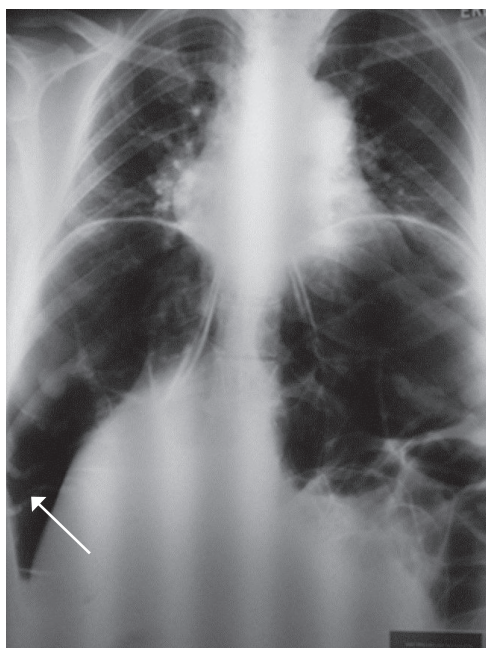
Chest radiograph of MAL showed diaphragmatic interposition of the colon. Note the haustra of the colon (*arrow*)
